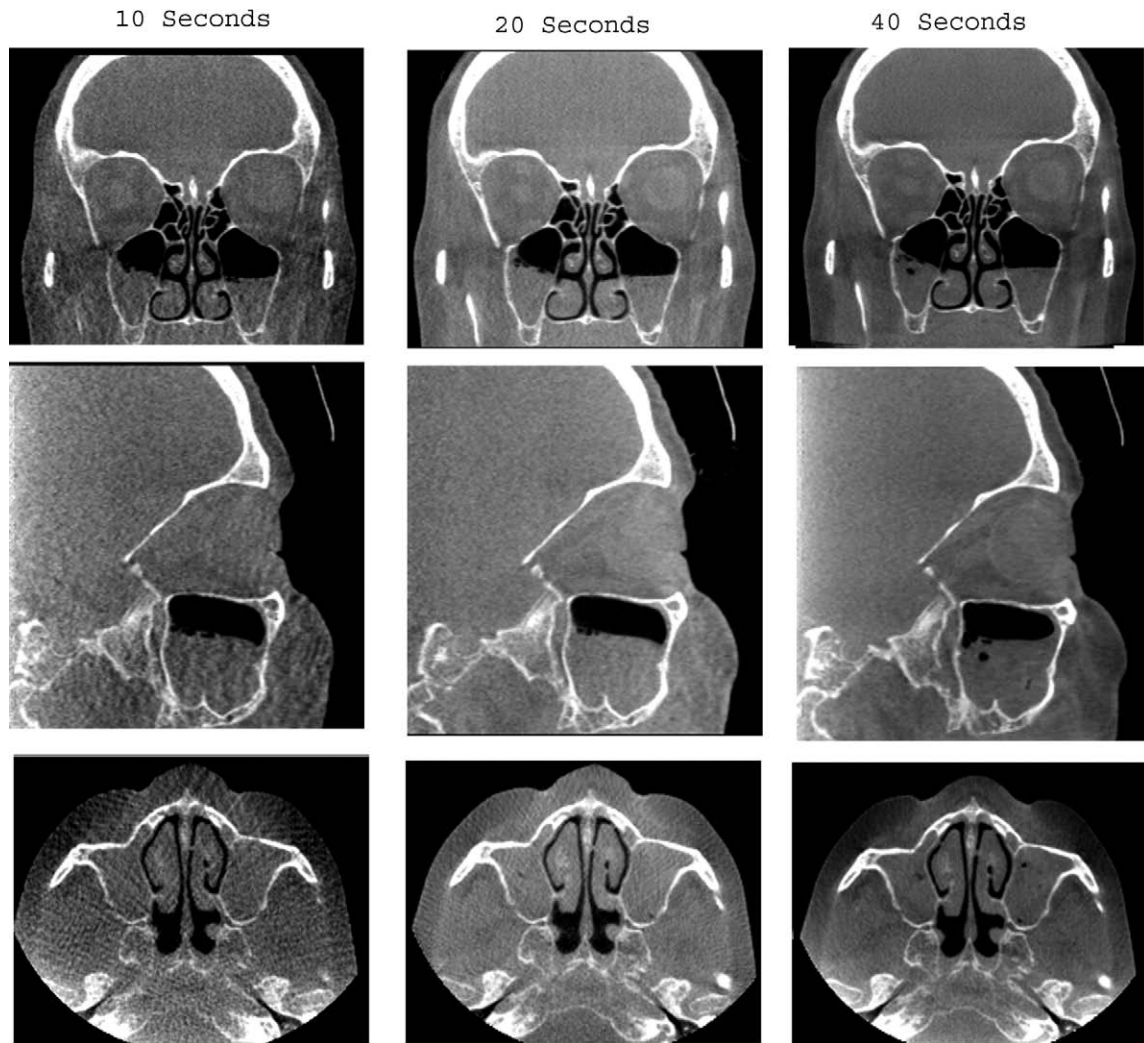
Coronal, sagittal, and axial CT images obtained with the low (10 sec), medium (20 sec), and high (40 sec) dose protocols.
